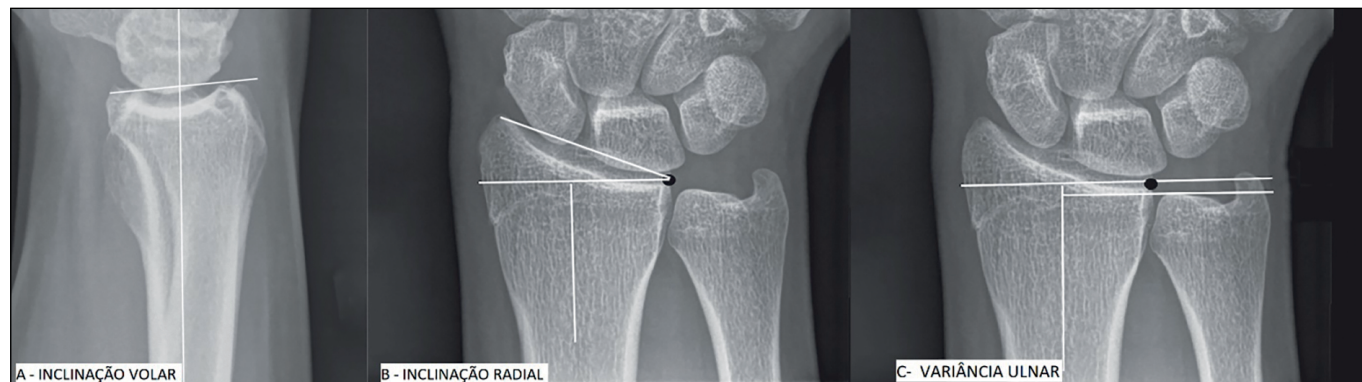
Measurements of radiographic parameters of the distal radius. A - Volar tilt. B - Radial inclination. C - Ulnar variance².
